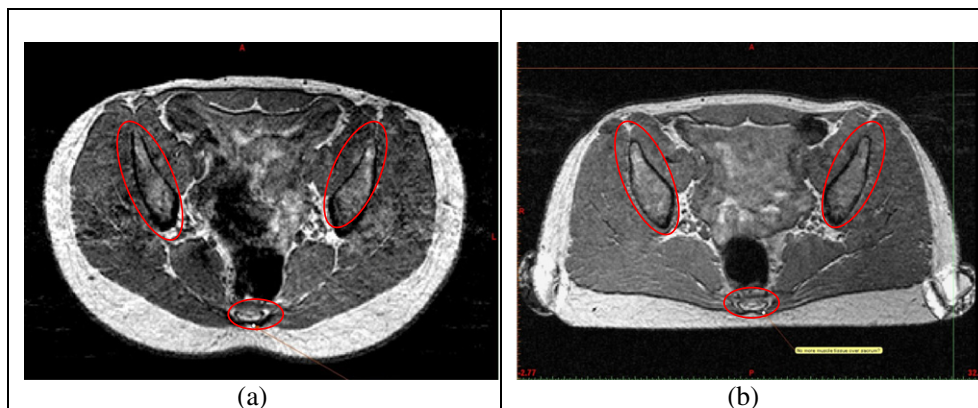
a) High resolution MRI made close to the sacral area in a prone position, b) resolution MRI made close to the sacral area in a supine position. Red ovals exclusively represent areas with bony tissue.
